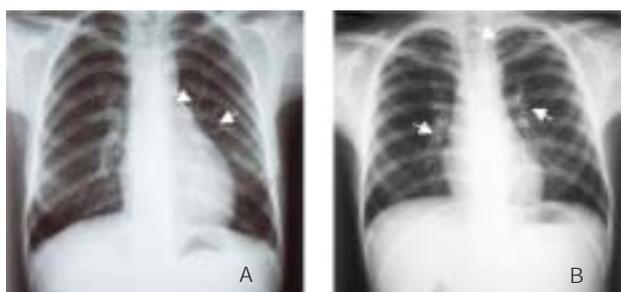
Chest radiographs of two patients: case A (Lt lung) shows ring-like cysts (arrows) with eccentric wall thickening (A, case 1) while case B (Lt lung) shows oval ring shadow with speckled calcification (arrows)(B, case 2).
